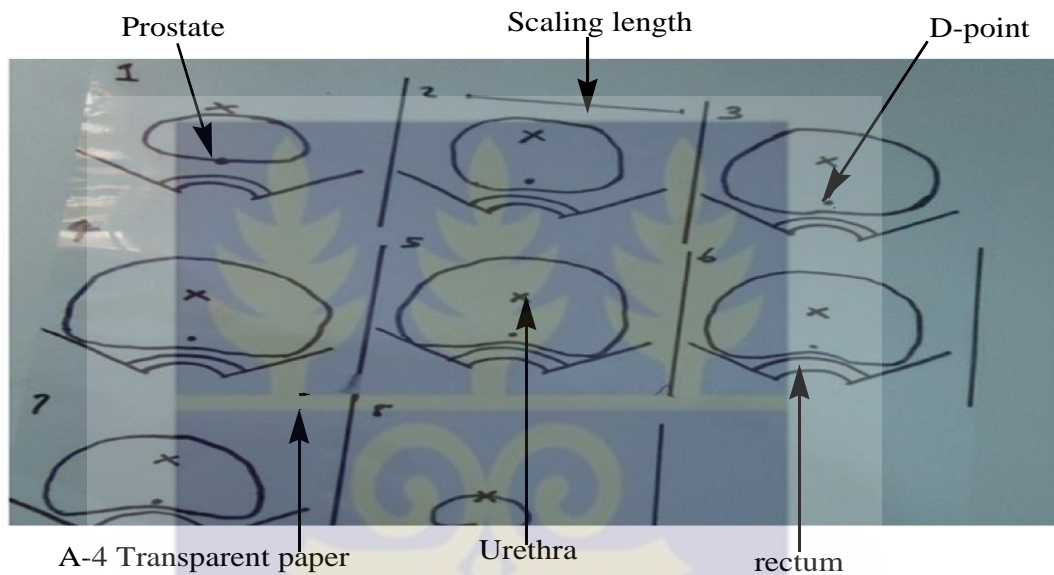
A picture of A4-sheet with ultrasound slices as numbered from 1 to 8. The D-points are there to outline the urethra in the straight line.
